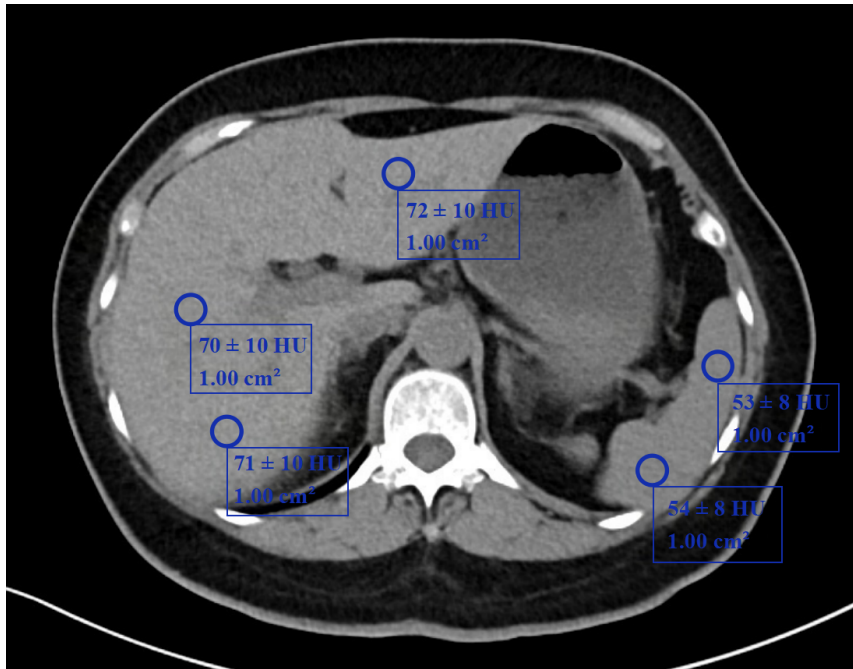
Measurement of liver and spleen attenuation on non-contrast CT. Hounsfield units (HU) were measured in three regions of interest (ROIs) within the liver and two within the spleen, with each ROI sized 1 cm². The liver-to-spleen (L/S) ratio was calculated by averaging the HU values of the liver and spleen, respectively. All measurements were performed at the level of the T12 vertebra. A representative non-contrast abdominal CT image is shown.
